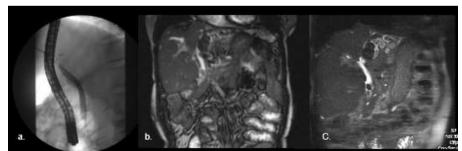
a. ERCP and MRI (b. coronal trufi, c. thick slab) demonstrating evidence of Choledocholithiasis
